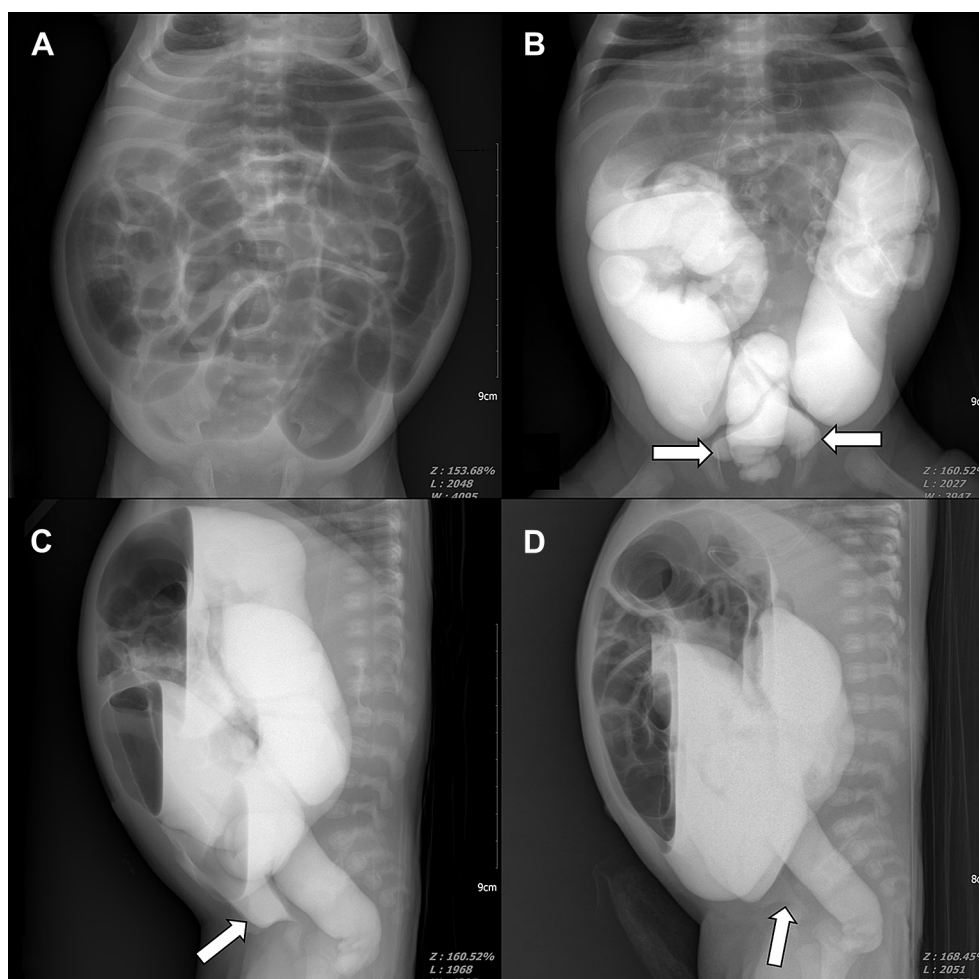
(A) A 28-day-old boy with severe abdominal distention. The initial supine abdominal radiograph shows abdominal bulging and gaseous distention of the bowel with no gas in the rectum. (B) Supine and (C) cross table lateral abdominal radiographs are taken 8 hours after the colon study. The contrast filled the colon, and the urinary bladder is opacified in front of the rectum that is demonstrated well on both views. (D) Cross table lateral abdominal radiograph taken on the next day of contrast study. Although the density is decreased, the urinary bladder is still visible. The patient was diagnosed with Hirschsprung's disease by rectal biopsy that revealed an absence of ganglion cells.
